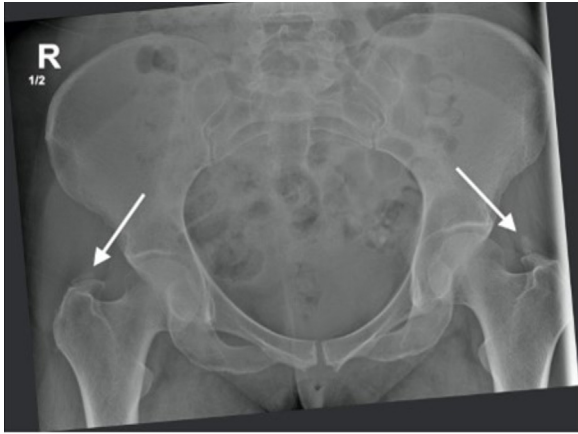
Pelvic radiograph. There are amorphous calcific densities projected over both greater trochanters (white arrows).
